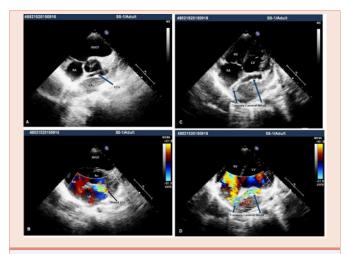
A and B. Parasternal short axis view showing dilated left circumflex artery (LCX) and enlarged right atrium (RA). C and D. Apical four chamber view showing fistulous flow from LCX to RA (arrow).
